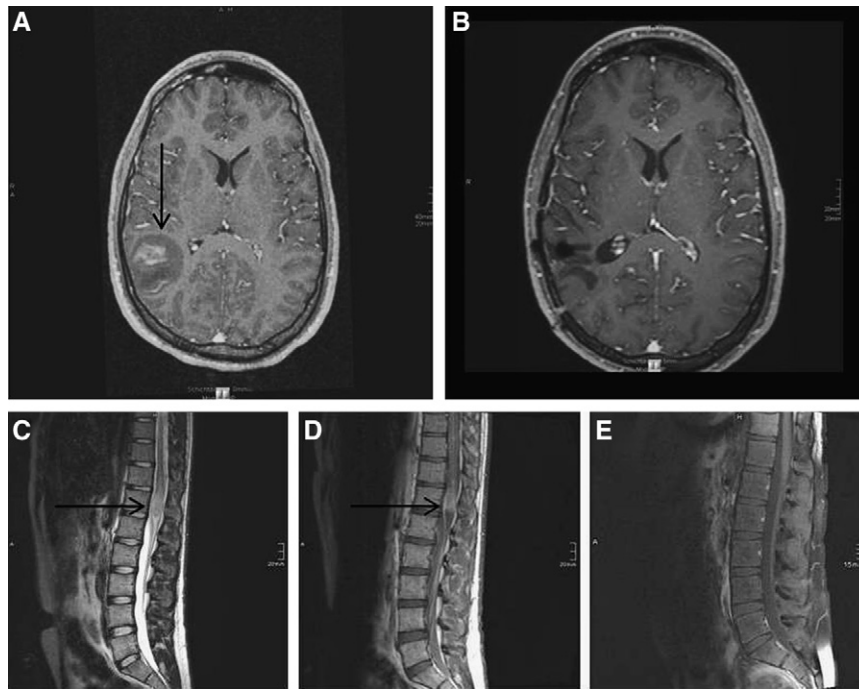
(A) Right parietal lymphoma at time of diagnosis; (B) complete remission after the first HDC-ASCT; (C,D) spinal lymphoma relapse; (E) complete remission after the second HDC-ASCT (A, B, D, E contrast-enhanced T1-weighted MRI; C, T2-weighted MRI).
